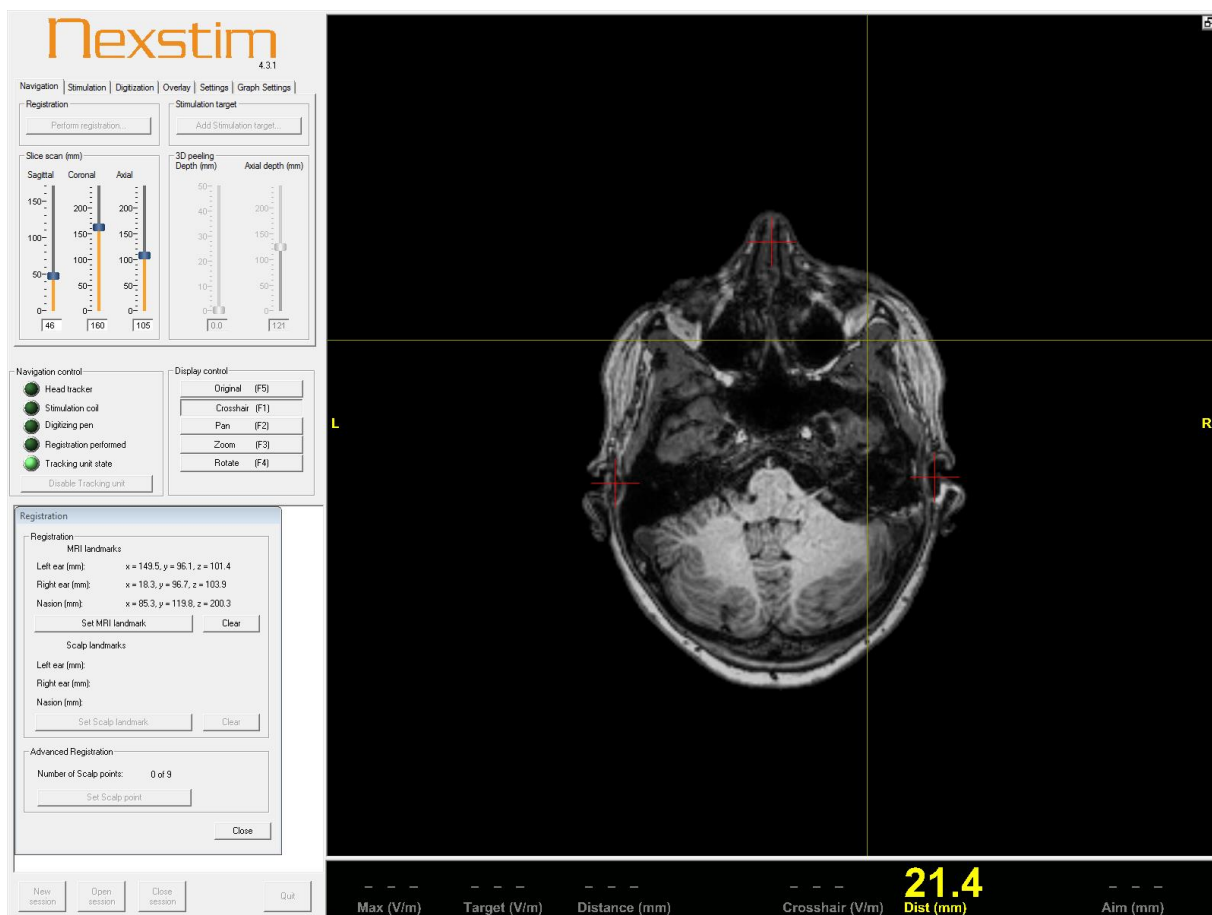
Display of the EntTMS device's software with the fiducial spots entered into the system. Note the markers' MRI coordinates displayed on the bottom left.
